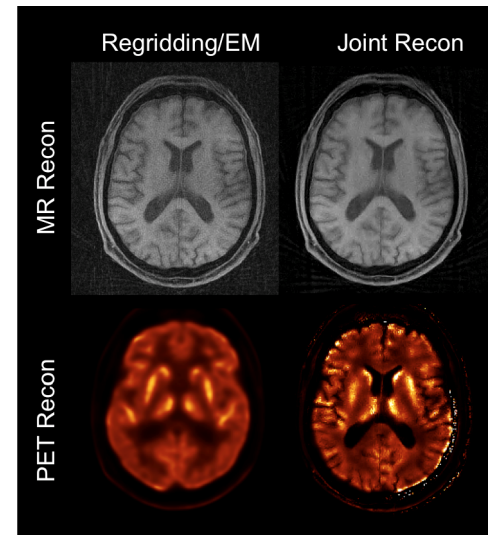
Regridding and EM reconstructions (left) and the proposed joint reconstruction (right) for the in-vivo brain measurements. Top: MR images. Bottom: PET images.
